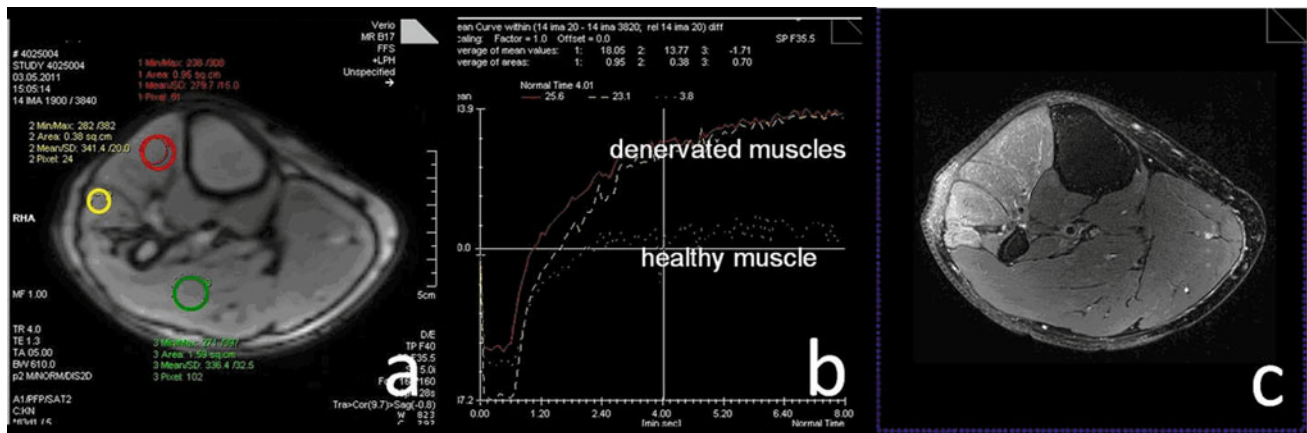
Perfusion MRI of denervated and healthy muscle. On the *left a* three regions-of-interest are displayed: *red* anterior tibial muscle, *yellow* long peroneal muscle, *green* lateral soleus, and gastrocnemius muscle. In the *middle b* three signal-intensity-time-curves are displayed with two upper graphs (*red* and *yellow*) corresponding to anterior tibial and long peroneal regions, whereas the lower curve corresponds to the gastrocnemius/soleus region-of-interest (*green*
